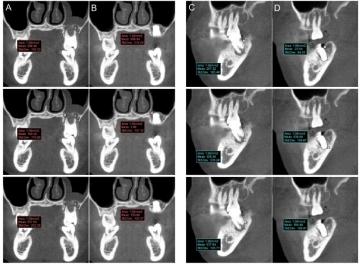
CBCT scan pre-surgery (a), 3 months post-surgery (b) and 6 months post-surgery (c)
